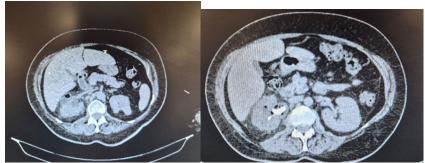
Air images in the right kidney on non-contrast abdominal CT.
